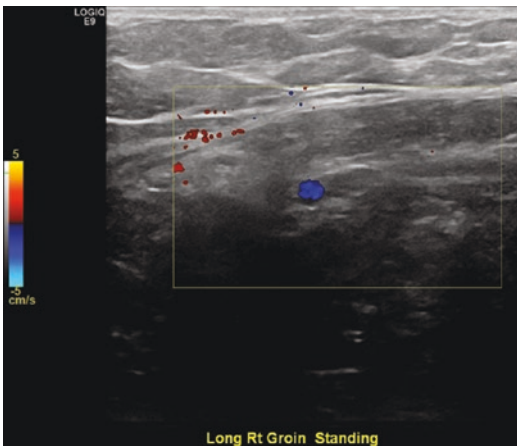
Doppler longitudinal view of a fat containing indirect inguinal hernia. The inferior epigastric vessel is seen as a blue circular image
